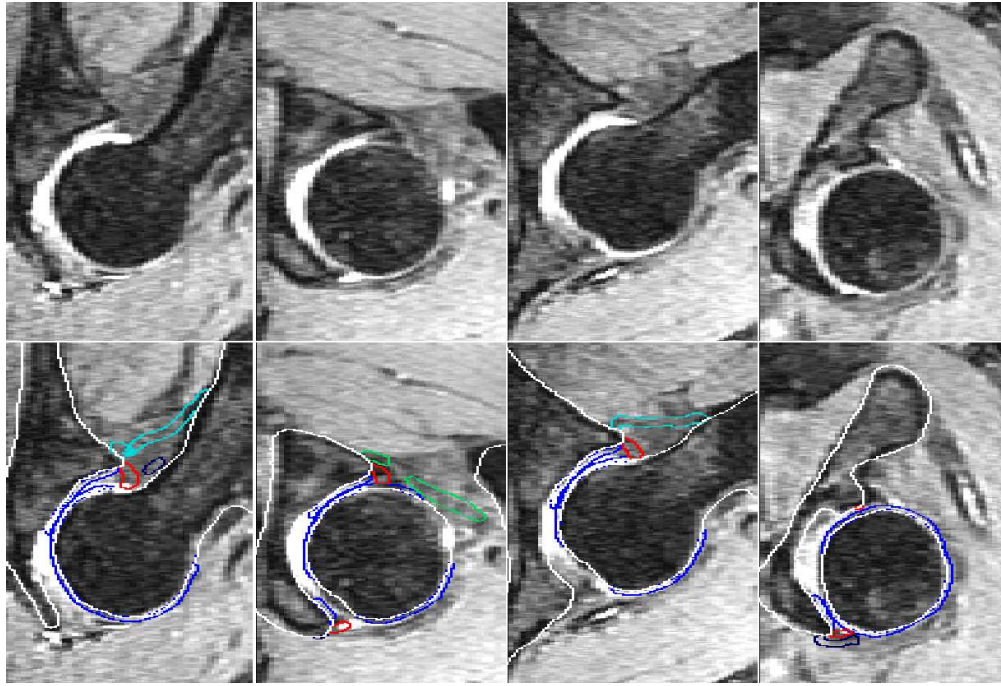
Cartilage/ ligament automatic segmentation on sample MRI slices around the hip (split posture)
